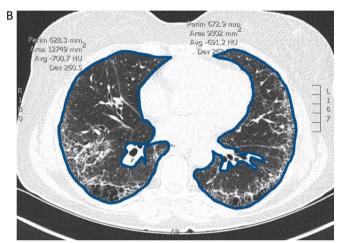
(A): Measurements of lung fibrosis on one HRCT slice made as an example. The area was measured by manually tracking the fibrotic area (marked in red). (B): Measurement of total lung volume on one HRCT slice made as an example. The area was measured by manually tracking the lung area (marked in blue).
